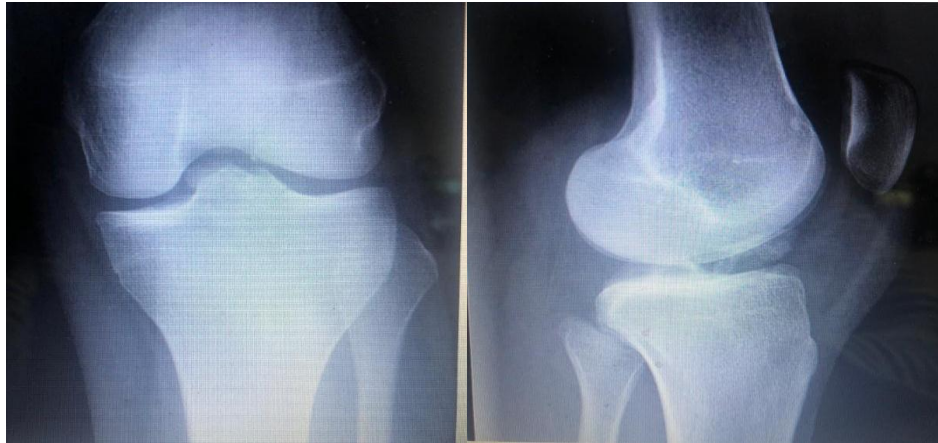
X-ray of the knee face and profile shows a tearing of the tibial spines.
